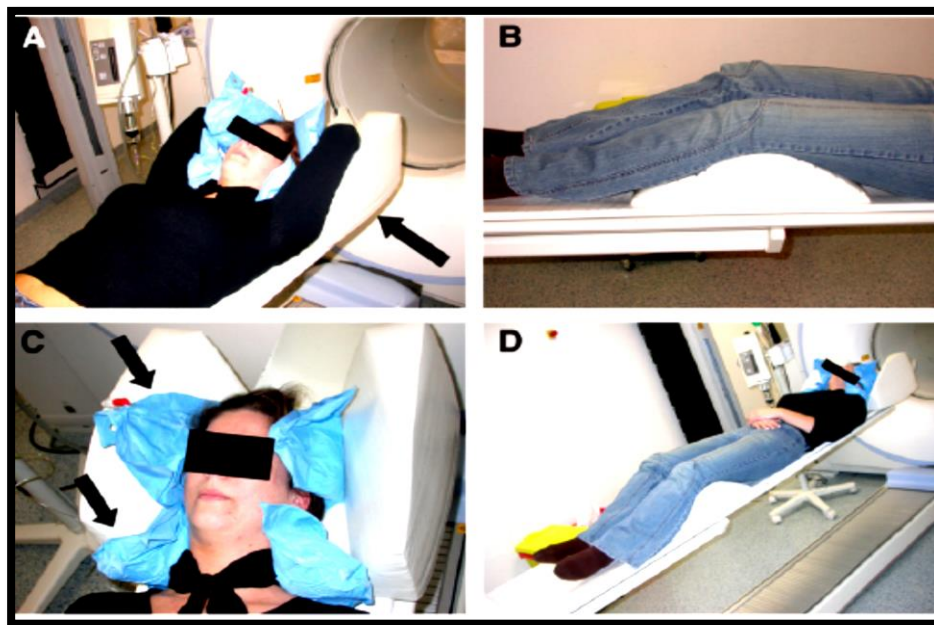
Patient supported with different positioning aids on PET/CT table. (A) For whole-body PET/CT, arms are raised above head and supported by foam cushion to avoid truncation artifacts during scanning of thorax and abdomen (arrow). Furthermore, head is placed within foam cushion and may be additionally supported with vacuum-lock bag to prevent head motion (blue vacuum lock bag). (B) Legs are supported by another foam mold to inflect patient's knees and to ensure comfortable positioning during scanning. (C) For head and neck scanning, vacuum-lock bag is deflated to fix head and neck within foam cushion (arrows). Thus, possible moving artifacts can be avoided. (D) Additionally, arms are placed on or beside patient's trunk to avoid truncation artifacts in head and neck area (13).
